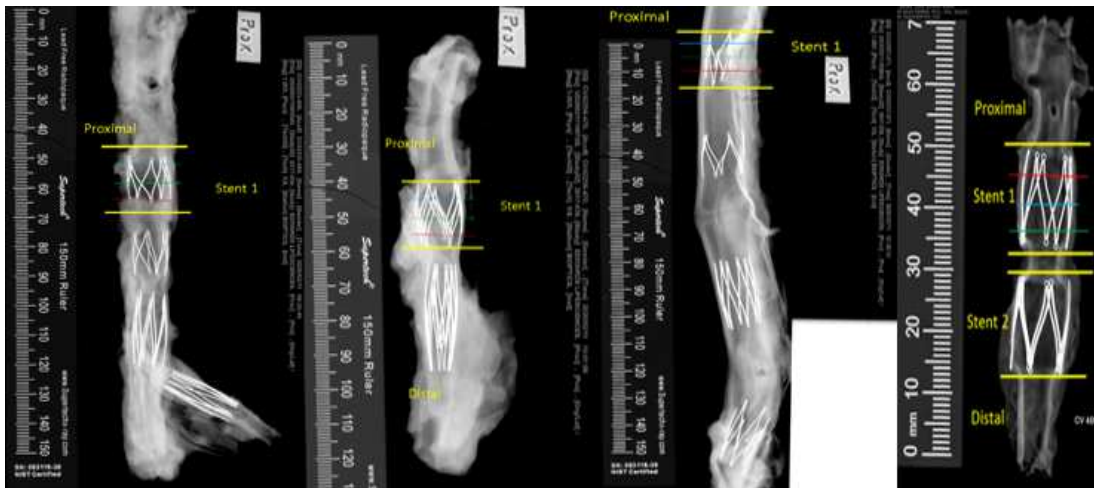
Orthogonal radiographic images. Representative image of orthogonal radiographic of all the stents. Lines show the proximal, middle, and distal side of Stent# 1. all the stents are well opposed and widely expanded without any intraluminal thrombus.
